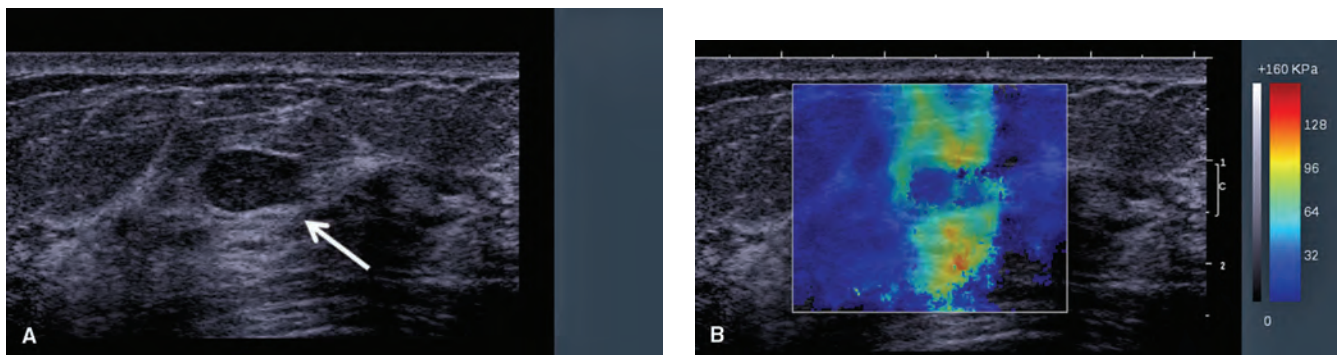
Shear-wave elastography: 53-year-old woman. (A) Predominantly circumscribed mass on standard B-mode ultrasound (*arrow*) originally called probably benign BI-RADS 3. (B) Surrounding tissue was shown to be stiff on shear-wave elastography. Therefore, biopsy was performed. Pathology revealed grade 1 infiltrating ductal carcinoma with ductal carcinoma *in situ*. (Courtesy of Dr. Christophe Tourasse via Dr. Wendie Berg.)
